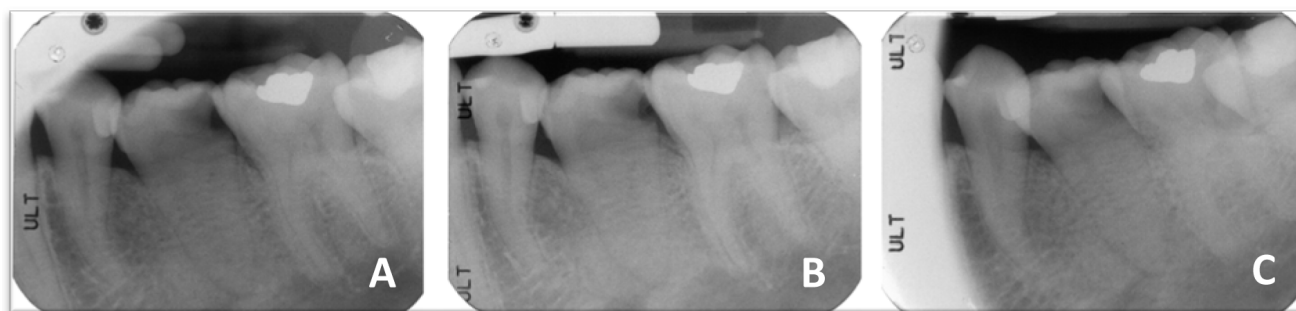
Periapical parallel radiographs of mandibular left second premolar with gemination were taken from different horizontal angles- mesial shifted (A), straight-on (B), and distal shifted (C). Deep proximal caries was found on the distal side, and a large pulp chamber was observed. Mesial and distal root canals were visible separately at the coronal two-thirds but joined at the apical level. Only one large, the conical-shaped root was noticed.
